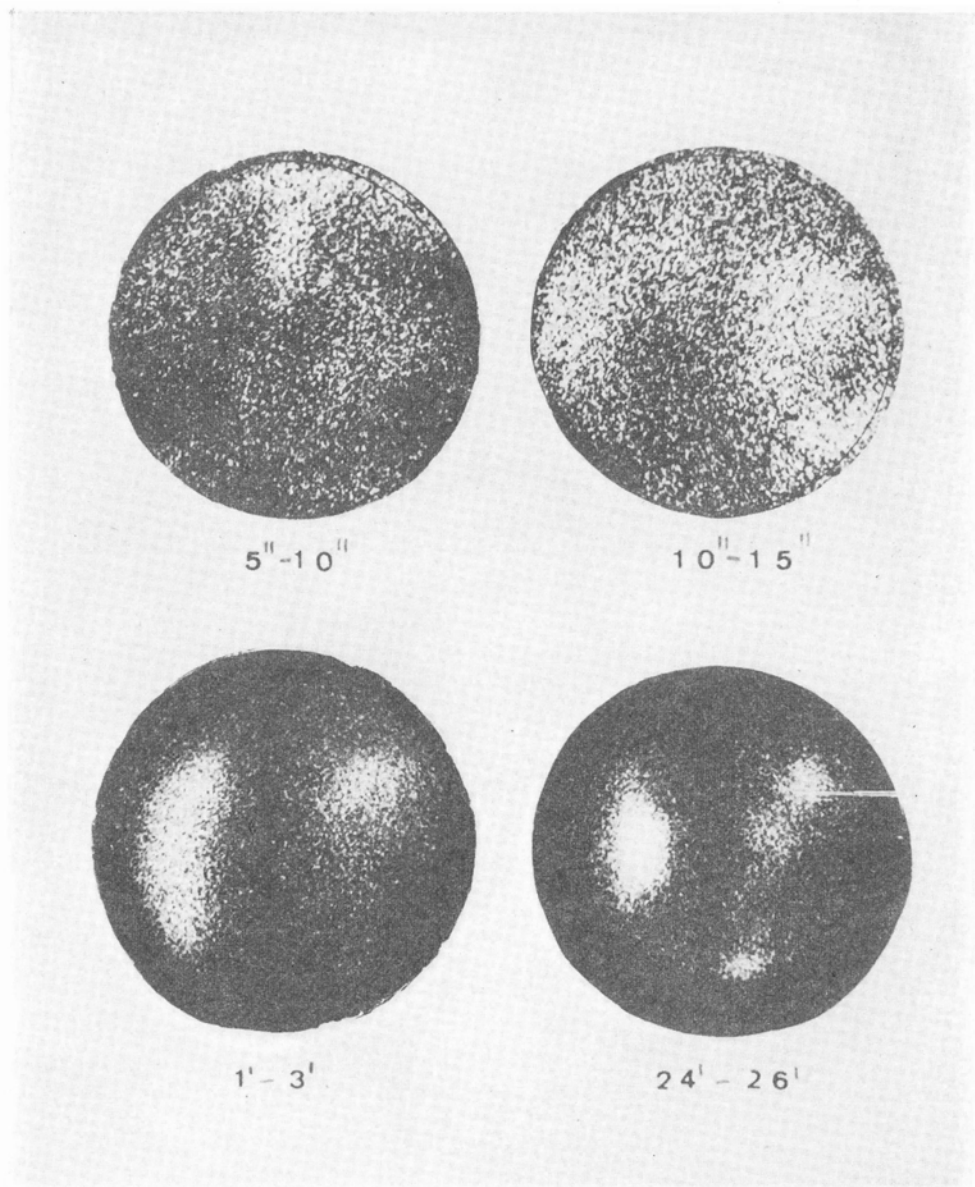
a) Angioscintigraphy after $^{99m}\text{TcO}_4$ (bottom) and serial scintigraphy after ^{131}I -o-Iodohippuric acid (below) in a patient with hypernephroma of the right kidney: high vascularization in a region thereafter missing any uptake.
